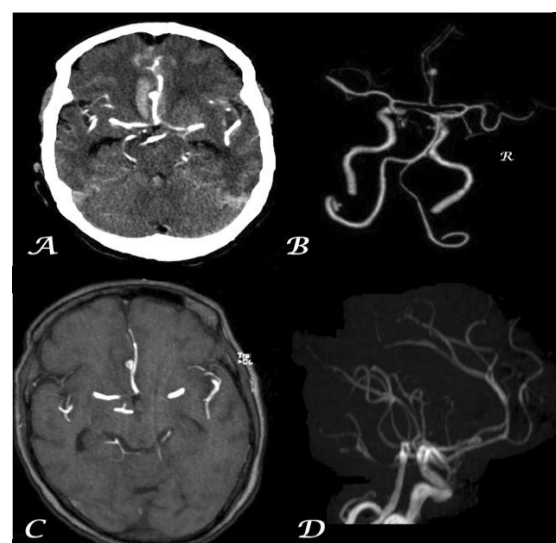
CTA (A – source image & B – Volume-rendered) and non-contrast MR TOF (C - axial & D – MIP) images show saccular aneurysm arising from right ACA (A2 segment)
